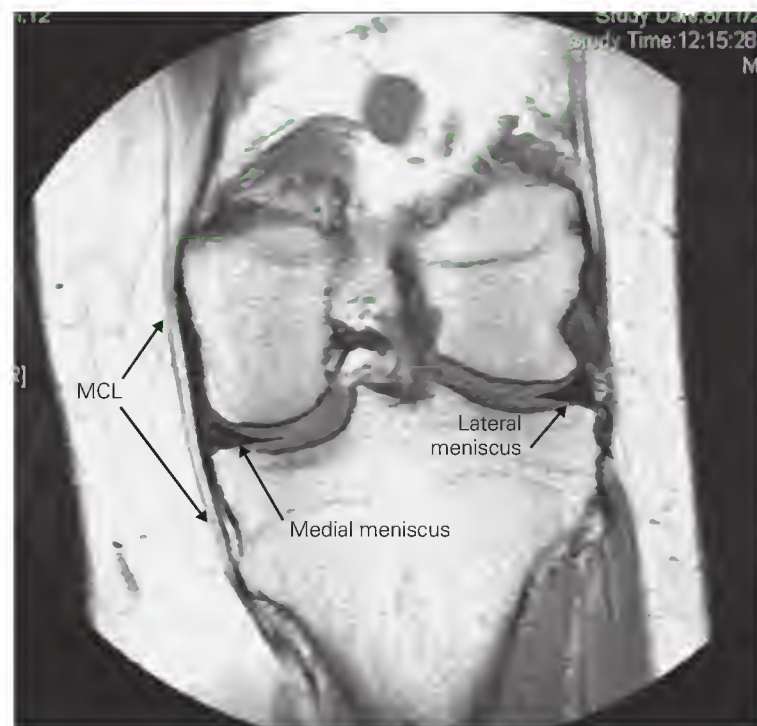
Coronal magnetic resonance image demonstrating the medial collateral ligament (MCL) and menisci ligaments.
